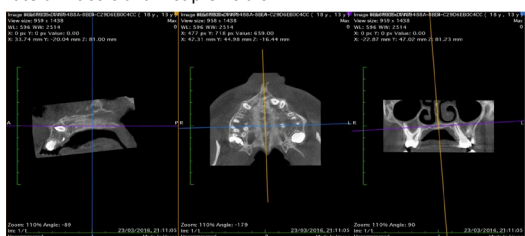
CBCT reconstruction: (software Horos Project) central, lateral incisors and first premolars positions in three planes of space (rotation, mesiodistal and buccolingual angulation).
